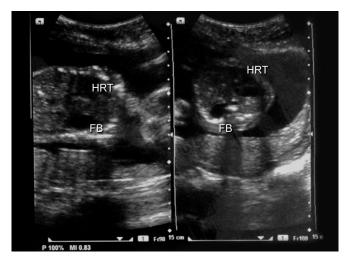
Prenatal ultrasonogram at 24 weeks gestation and stomach fundic bubble (FB) at the same cross-sectional level as the heart (HRT) suggestive of congenital diaphragmatic hernia
